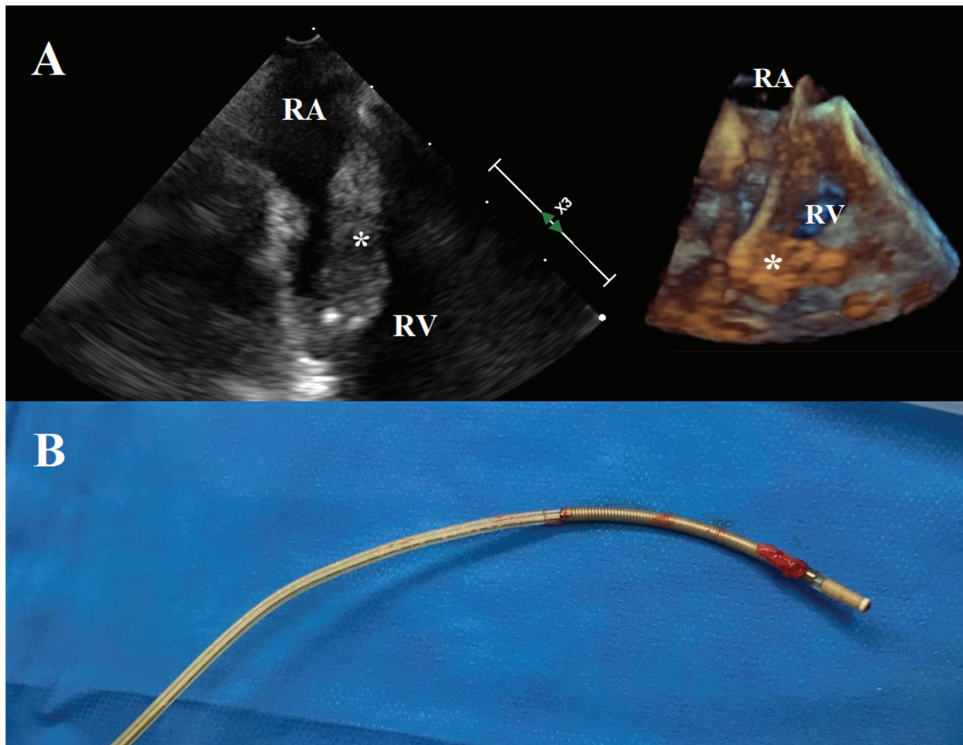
Intraoperative echocardiographic view of large lead vegetations (30 mm × 90 mm, Panel (A)). Extracted PM lead (Panel (B)). RA: right atrium. RV: right ventricle. *: vegetation.
